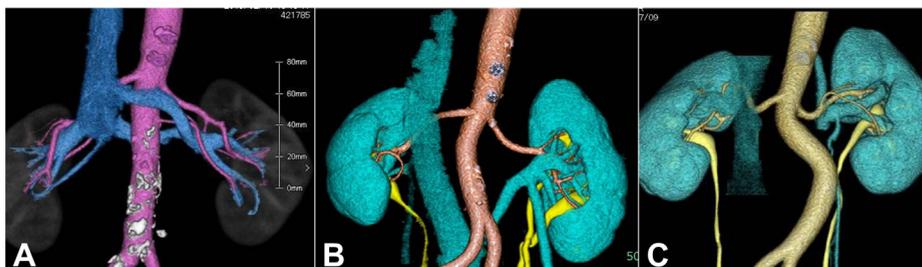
Computed tomography findings showed circumaortic left renal vein (A), retroaortic left renal vein, Case 3 (B), and left renal vein drainage into hemiazygos vein, Case 6 (C).
